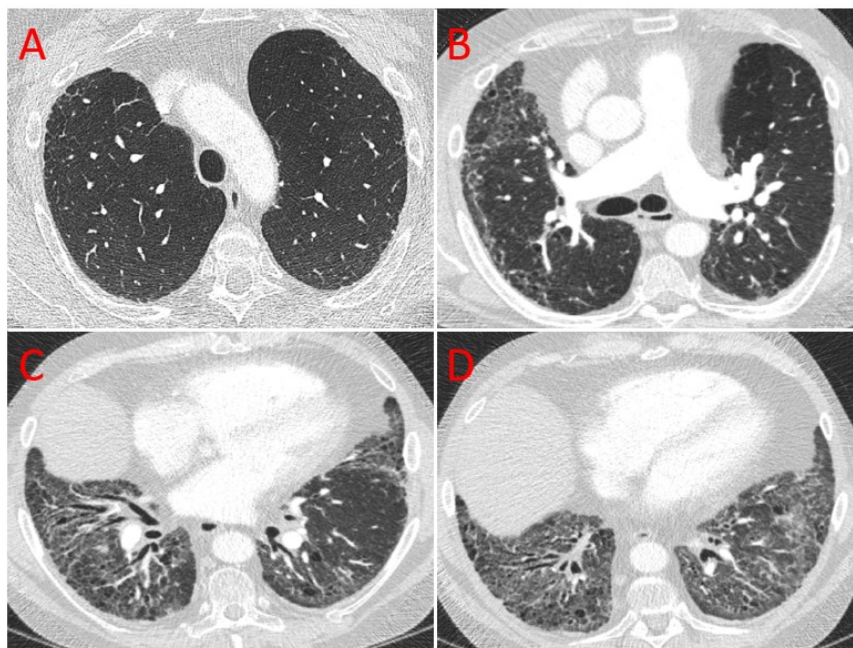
High resolution CT dicom's from a patient with Non-specific interstitial pneumonitis from the ILD-PH cohort.
